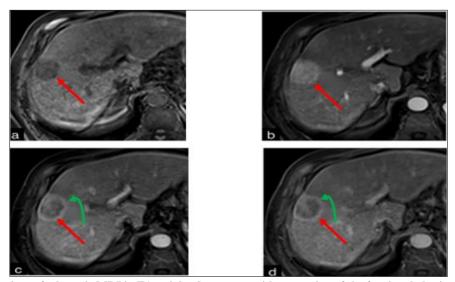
Axial sections of a hepatic MRI in T1-weighted sequence with saturation of the fat signal obtained before and after injection of gadolinium at the following phases: arterial (a), portal (b), and delayed (c), showing a mononodular HCC in hyposignal T1 with hypervascularization at the arterial phase, a washout at the portal and delayed phases, surrounded by an enhanced capsule at the portal and delayed phases (ART: lirads)
